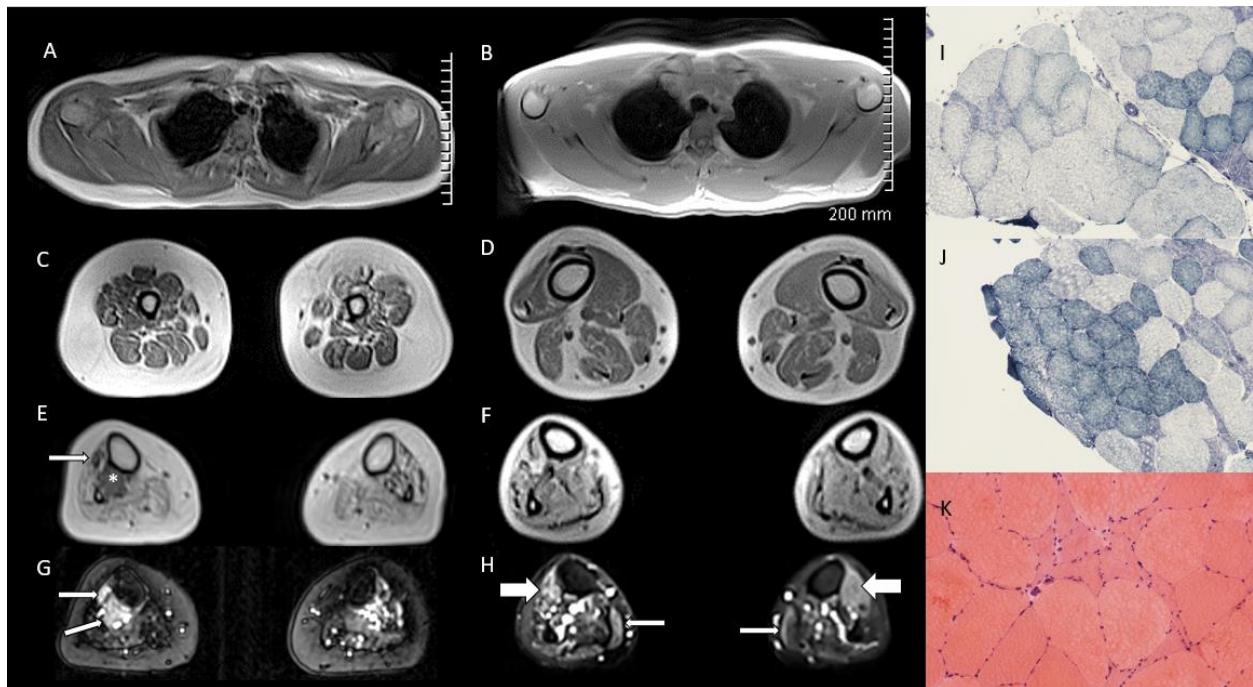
Distal denervation atrophy on muscle MRI and muscle biopsy
